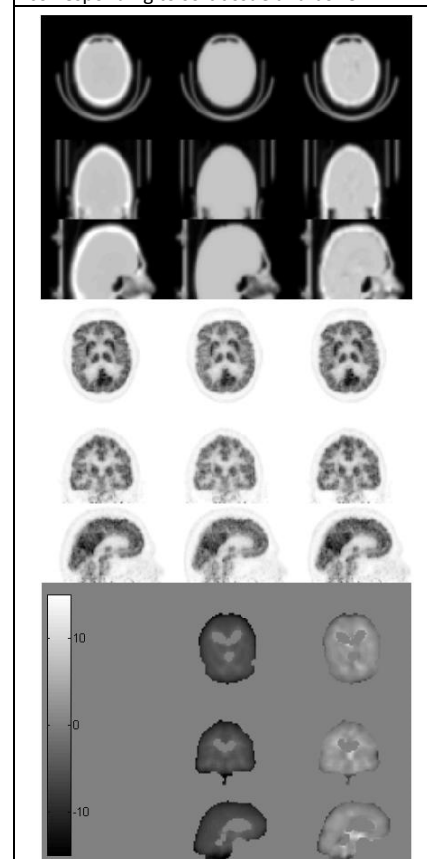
PET attenuation maps (top), PET emission images (middle), relative error maps (bottom) for CT-AC (left), segCT-AC (middle) and ZT-AC (right).
